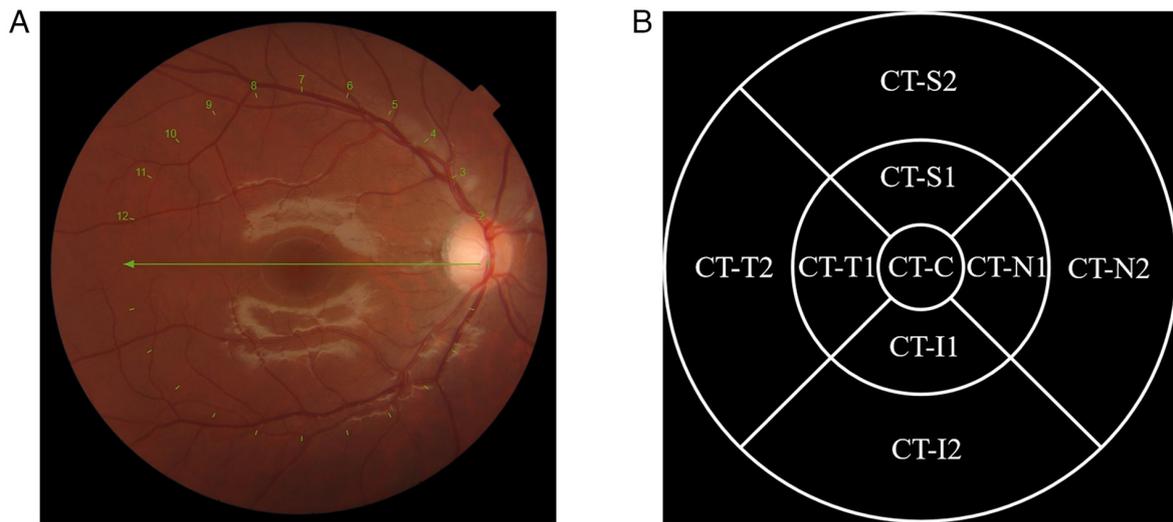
Measurement of CT. (A) Imaging of CT during optical coherence tomography scanning. (B) The scanned area was divided into different regions in the form of quadrants, including the following regions: CT-C, CT-N1, CT-N2, CT-T1, CT-T2, CT-S1, CT-S2, CT-I1 and CT-I2. Numbers 1 to 12 indicate the positions of the captured images. CT, choroidal thickness; CT-C, CT at the centre of the macula; CT-N1, CT at 0.5 mm nasal; CT-N2, CT at 1.5 mm nasal; CT-T1, CT at 0.5 mm temporal; CT-T2, CT at 1.5 mm temporal; CT-S1, CT at 0.5 mm superior; CT-S2, CT at 1.5 mm superior; CT-I1, CT at 0.5 mm inferior; CT-I2, CT at 1.5 mm inferior.
